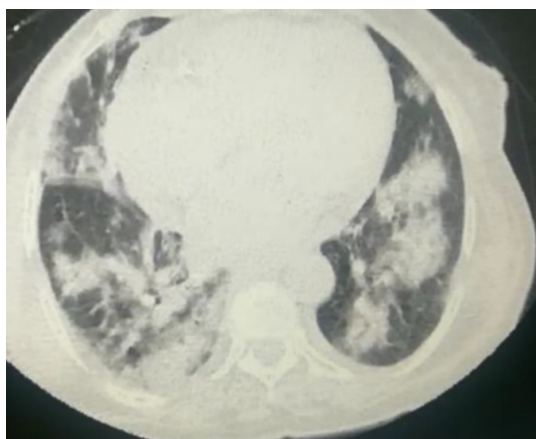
Bilateral patchy areas of consolidation with basal predominance this finding comprises 2% of the abnormal CT seen in one male [It represents patient after 5 days of symptoms/ increase severity of infection as all alveoli are loaded with inflammatory exudate, pleural effusion is present bilaterally]
